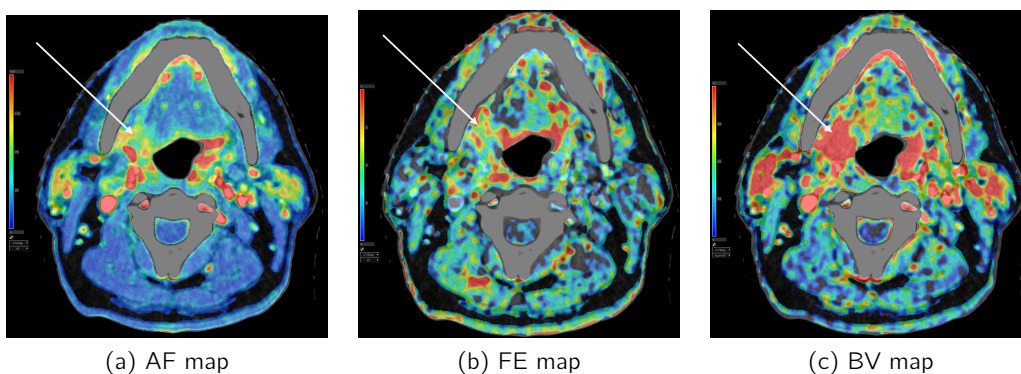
The tumour in the right tonsil loge on the three different CT perfusion maps of the follow-up scan.
